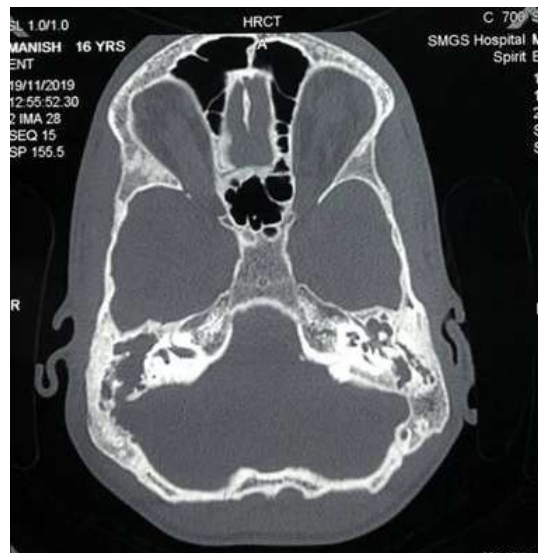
HRCT showing right sided Extra-dural abscess
